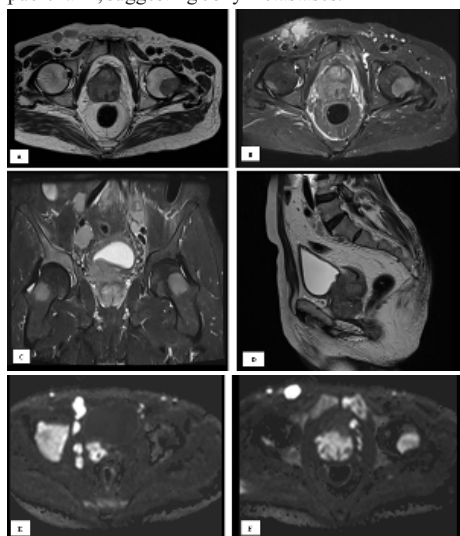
MRI showed a predominantly T2 hypointense mass lesion in the peripheral zone of base and mid-gland of prostate infiltrating the right neurovascular bundle and showing restricted diffusion. HPE report revealed the lesion to be adenocarcinoma of prostate
